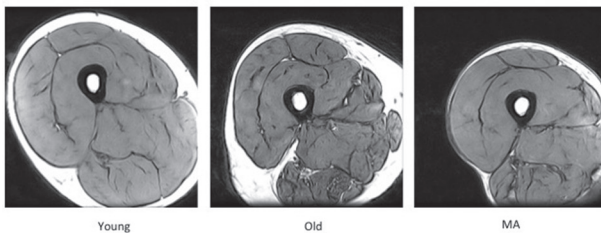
Vastus lateralis images of young, old and master athletes. Obtained from the mid-thigh using MRI.
